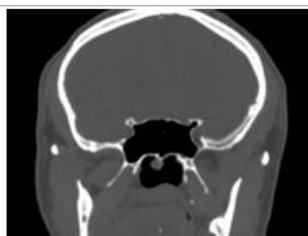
Coronal CT showing type II optic nerve (arrows)causing an indentation of the sinus wall, but without contact with the posterior ethmoid air cell
